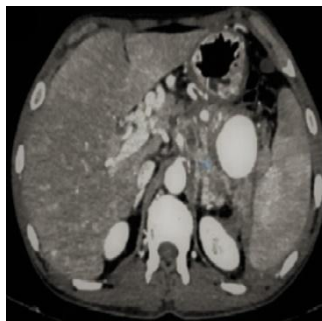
Contrast enhanced CT showing pseudoaneurysm of splenic artery in case of chronic pancreatitis
